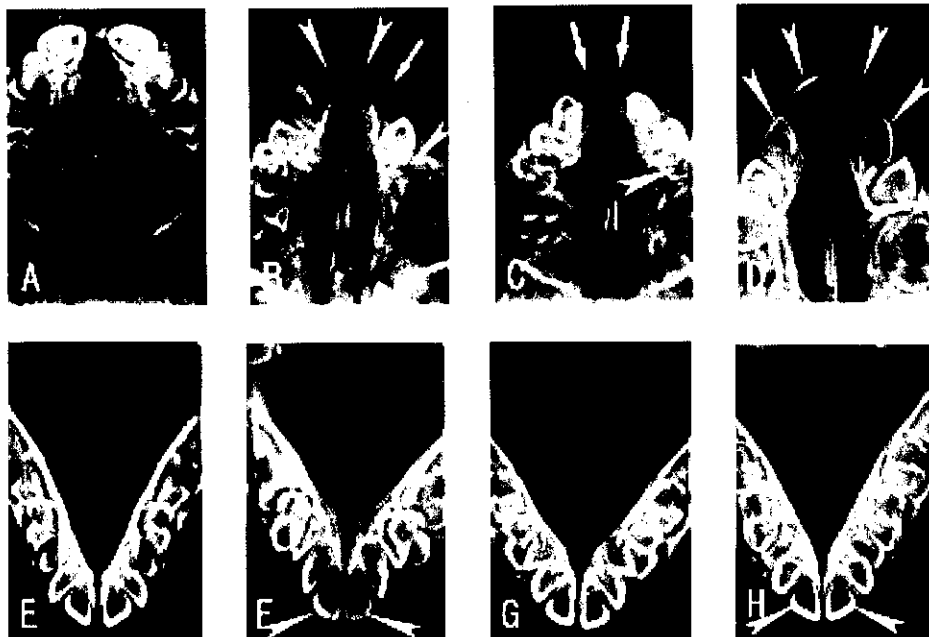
Conventional radiographs of jaws shown in Fig. 2. Radiographs are arranged corresponding to Fig. 1. Upper jaws (A-D) and lower jaws (E-H). Arrowheads and arrows indicate precocious eruption and missing teeth, respectively. Offspring numbers: A, E: No. 10; B, F: No. 37; C, G: No. 40; D, H: No. 57.
